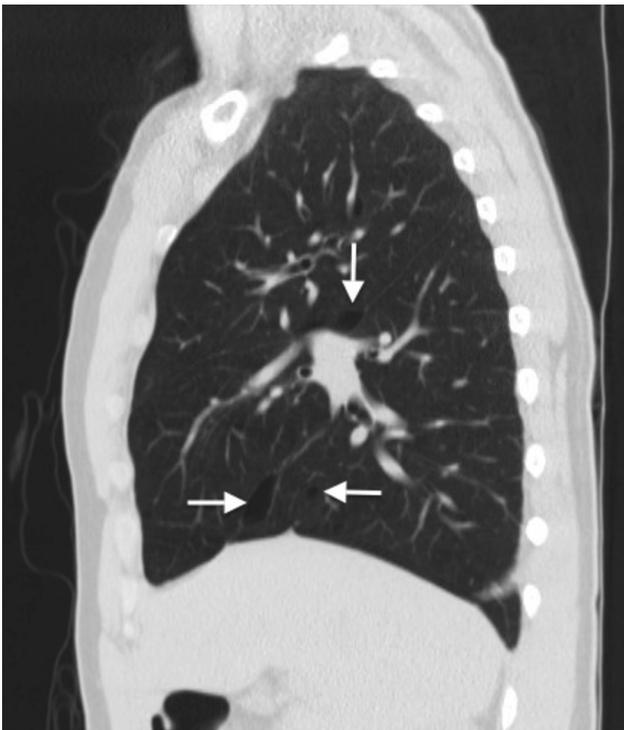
Sagittal computed tomographic (CT) image demonstrating numerous parenchymal cysts (arrows).
